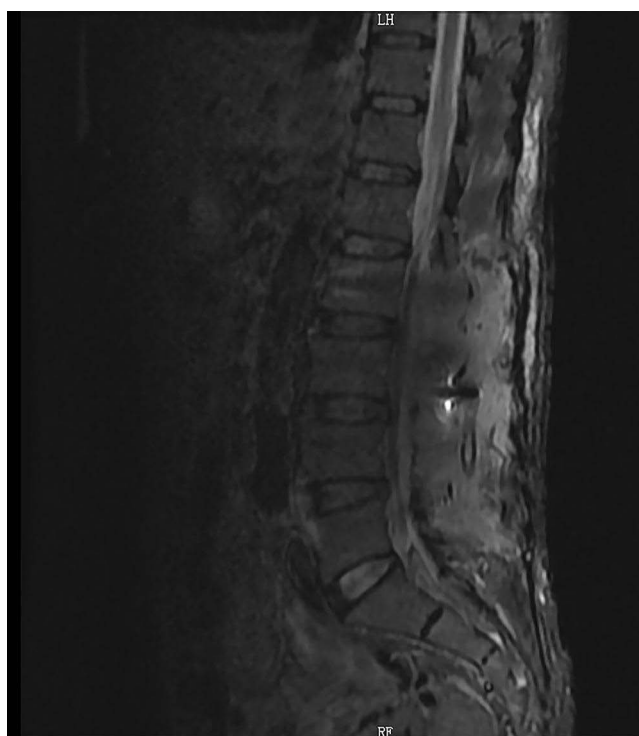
Postoperative MRI indicated that the L2-L5 intraspinal hematoma had been completely cleared.
